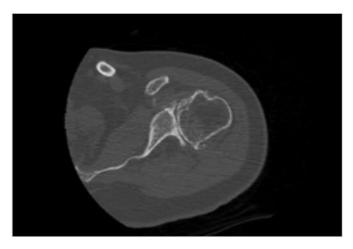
Preoperative axial computed tomography image for case 1.
